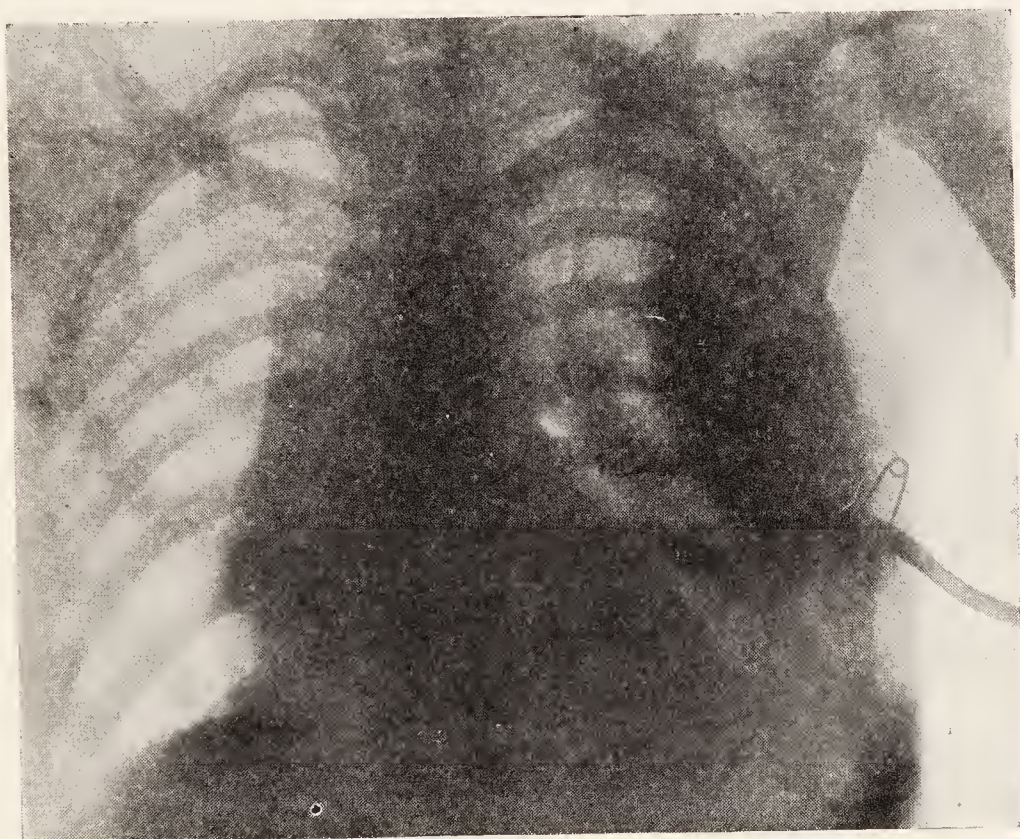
Shows tip of catheter draining left pleural cavity. (Note the axillary position of the exudate.) Dr. Wyman Whittemore. (Roentgenological Department, Massachusetts General Hospital.)
